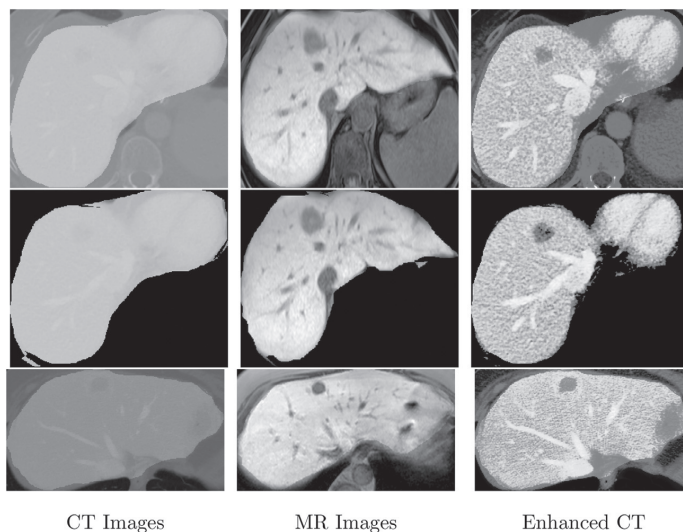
CT, MR and enhanced CT images showing tumors.
